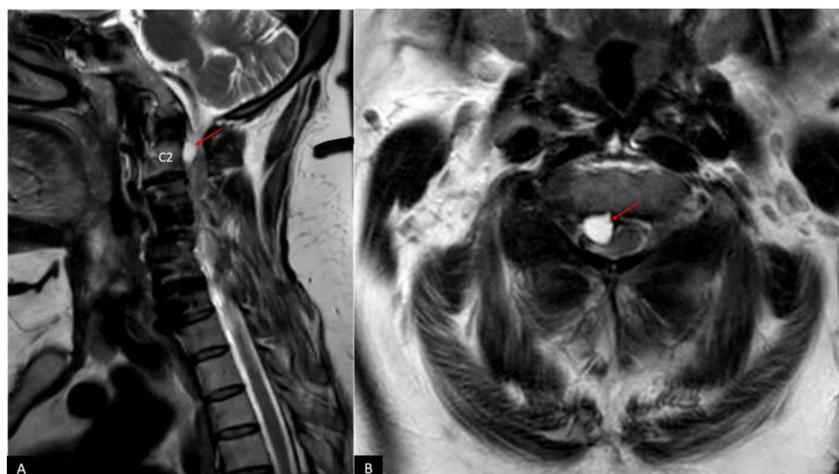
Preoperative sagittal (A) and axial (B) T2-weighted MRI depicting a retro-odontoid synovial cyst (red arrow) compressing the cervical spinal cord.
